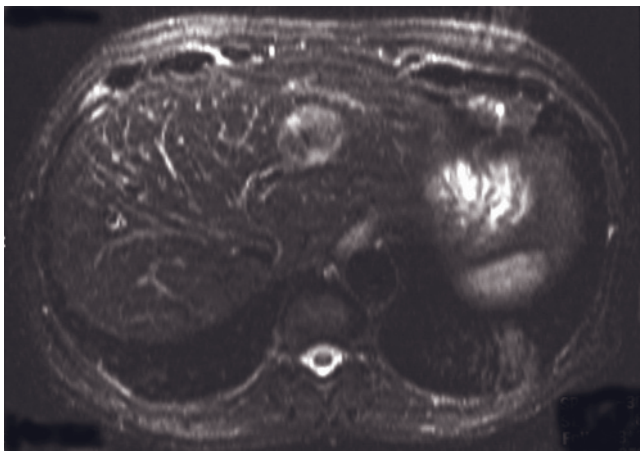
(Continued) Fat-suppressed T2-weighted SS-ETSE (e), SGE (f), and immediate (g), 45-s (b), and 90-s fat-suppressed (i) postgadolinium SGE images in a second patient with a tumor located in segment 8. This mass shows mildly high signal intensity on the T2-weighted image (e), mildly high signal intensity on the T1-weighted image (f), moderate enhancement on the early phase (g), and washout and capsule enhancement on 45-s image (b) that persist on late-phase image (i), consistent with HCC. Note that washout occurs by 1 min postgadolinium for HCCs, and excellent renal corticomedullary enhancement is still present when the tumor has washed out.
